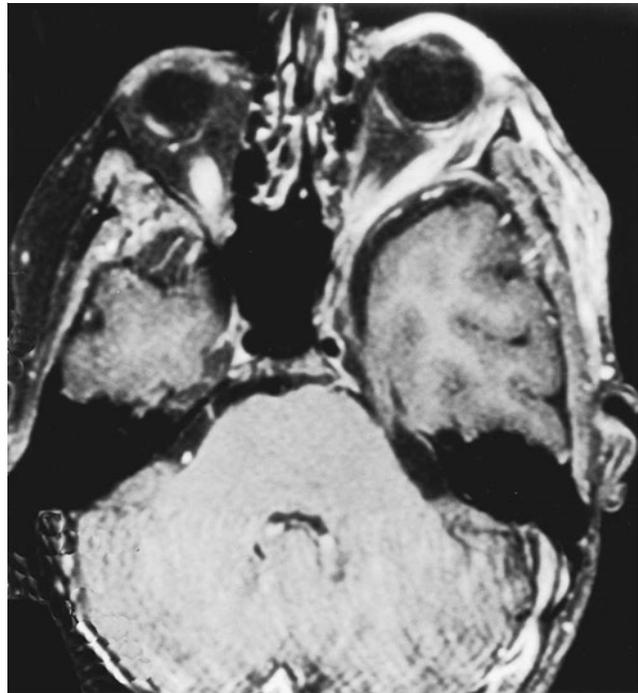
This axial T1-weighted magnetic resonance image shows left sphenoid dysplasia with protrusion of the temporal dura into the posterolateral orbit and resultant proptosis.
